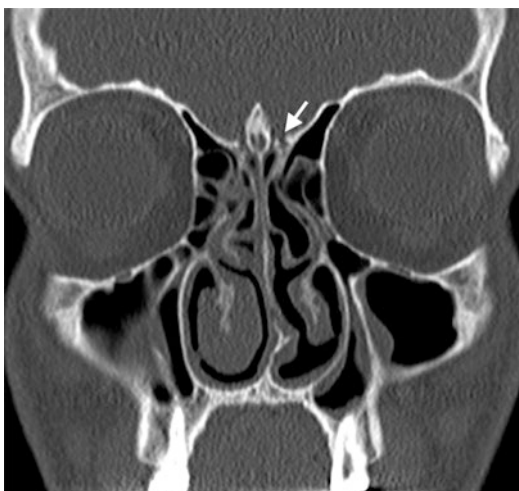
ASB fracture. Coronal CT image of a 18-year-old man with a history of assault demonstrates a fracture (arrow) involving left lateral lamella
